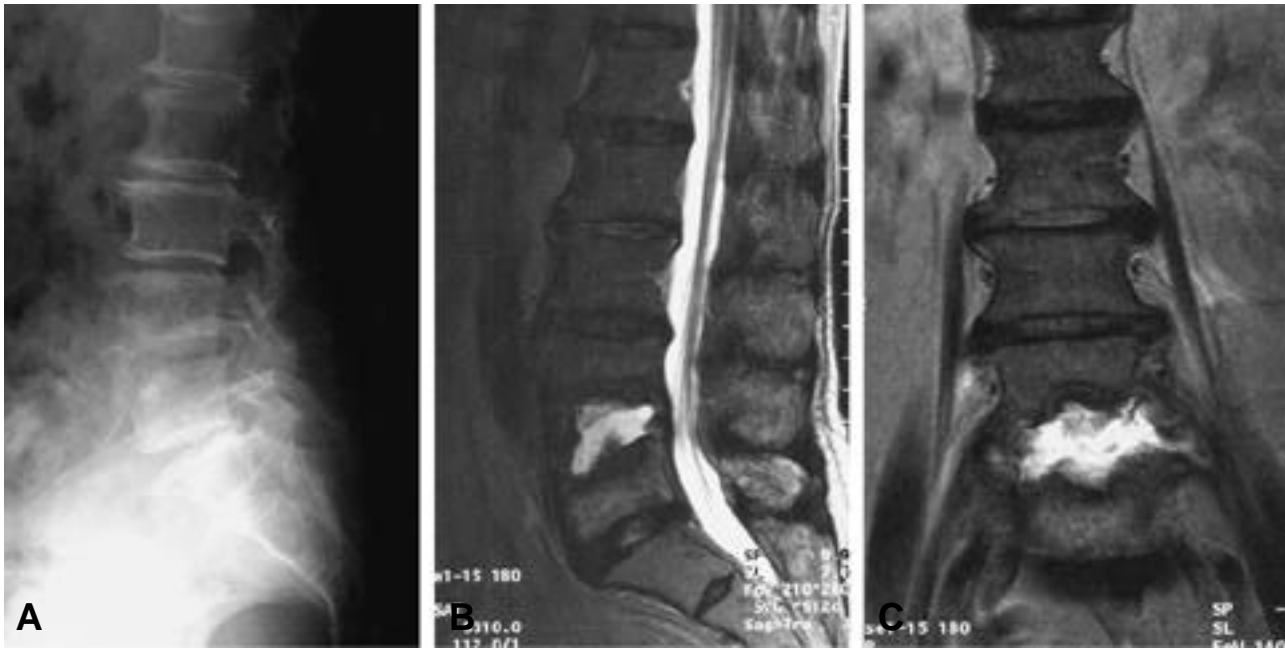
Lateral X-ray at 7 weeks post-PCD shows progression of bony destruction.
